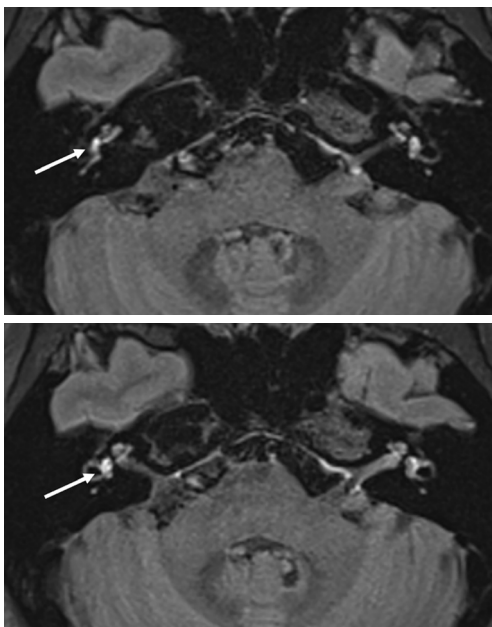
Postcontrast delayed 3D-FLAIR MRI revealing high signal intensity in the perilymph of the right vestibule. The solid white arrows indicate the vestibule. 3D-FLAIR MRI, 3-dimensional fluid-attenuated inversion recovery magnetic resonance imaging.
